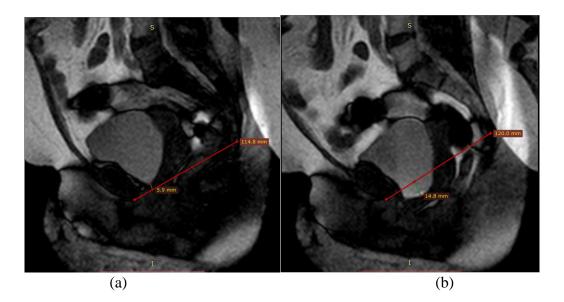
Sagittal BFFE MR image in a 55-year-old female (a) at rest and (b) at maximal strain show bladder neck descent below the pubococcygeal line (PCL) by about 14.5mm.
